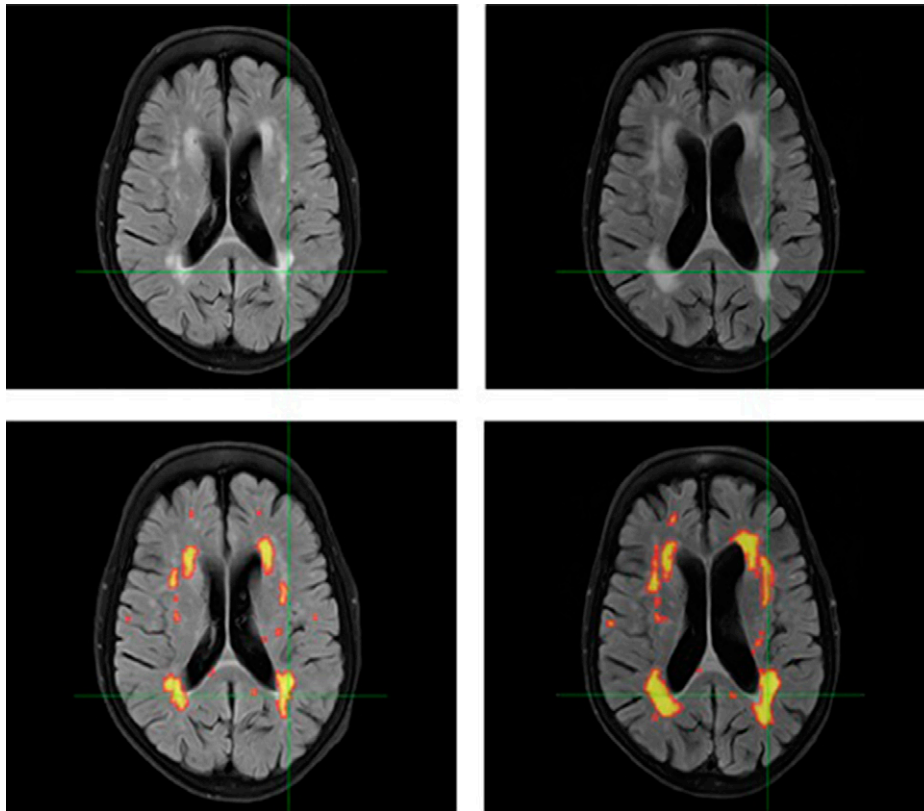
White matter hyperintensities progress in those on continued haemodialysis. The images on the left represent baseline MR images and on the right MR imaged at follow-up following 12 months of treatment. Additionally, a loss of cerebral volume can be appreciated as enlargement of lateral ventricles. This figure demonstrates visible progression of WMH on standard T2 fluid-attenuated inversion recovery sequences (top row) and after application of volumetric analyses software (bottom row).
